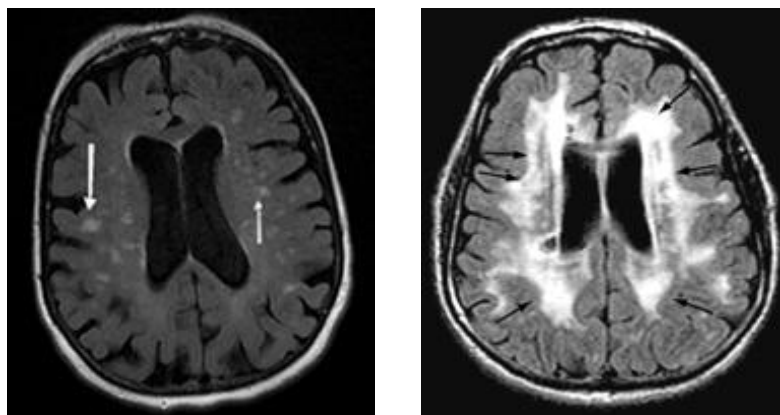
Pathological alterations of VaD. Multi-infarct sites (left); abnormalities in subcortical white matter, with multiple areas of abnormal high signal intensity (right) (MRI images). From http://dementiatypes.org/Vascular_Dementia.htm and Bird and Miller (2010).
